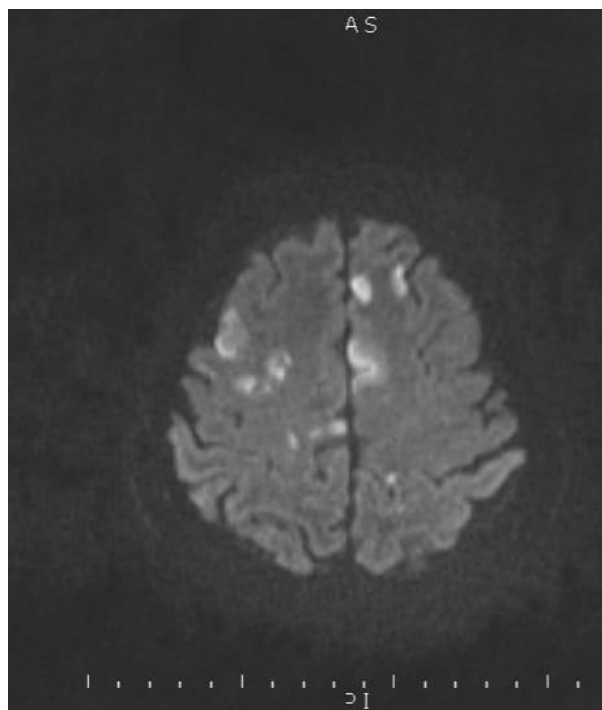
Regions of intracerebral occlusion on MR image sections-occipital, parietal and frontal lobes
